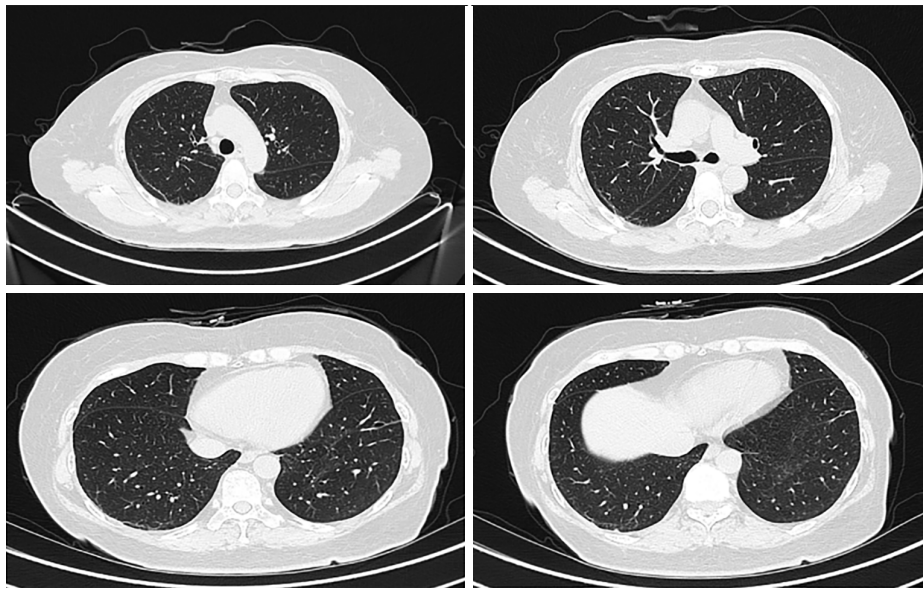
Results of the patient's chest CT examination. Chest CT showed no active lesions. CT, computed tomography.
